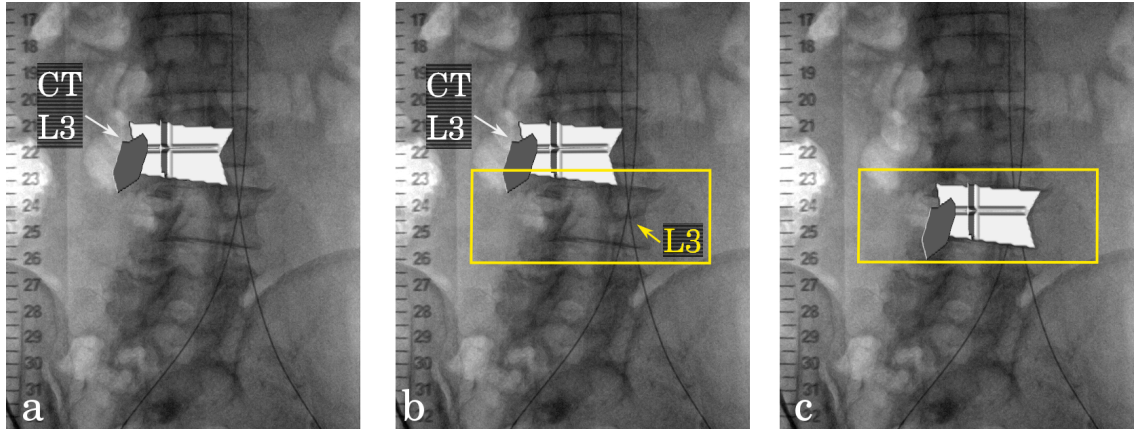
Defining the starting positions for the in-plane translation parameters using a graphical user interface. a) The fluoroscopy image and the segmented CT L3 vertebra surface. b) The corresponding L3 vertebra is visually identified in the fluoroscopy image, and a box is drawn around the chosen vertebra (yellow box). c) The CT vertebra surface is manually translated over the fluoroscopy vertebra and inside the yellow box to complete the process.
